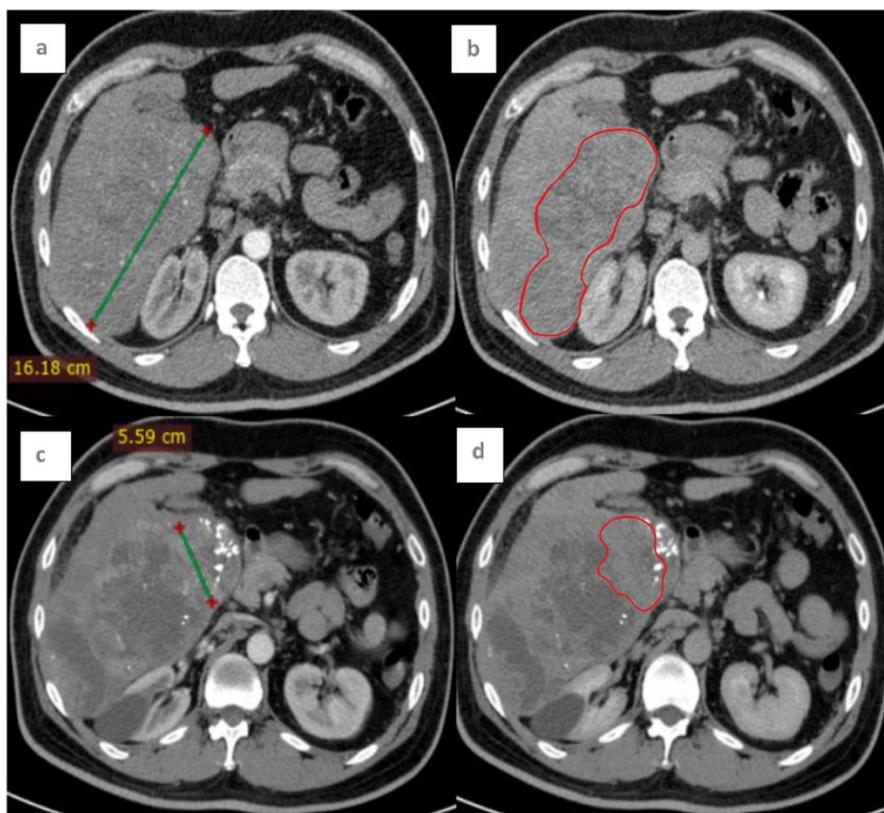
Example of mRECIST-based treatment response evaluation. Pre-TACE arterial (A) and delayed phase (B) CT images demonstrate a large hepatocellular carcinoma with a maximal diameter of 16.18 cm; the viable enhancing component is outlined. Follow-up CT after TACE (C and D) shows a reduction of the viable portion to 5.59 cm, representing a 65% decrease in viable tumor area and fulfilling the criteria for objective response according to mRECIST. The pre-treatment DPAR value for this case was 163.
